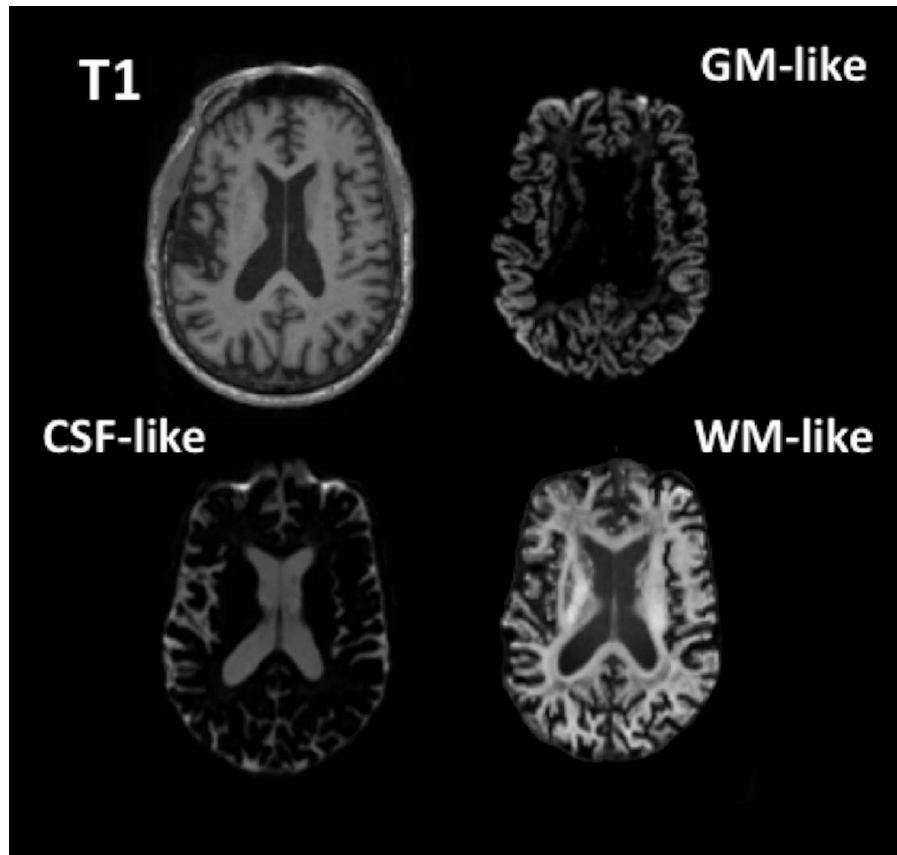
Axial slices showing a T1-weighted MPRAGE and the GM-, CSF-, and WM-like tissue compartments derived from the dMRI data using 3-tissue CSD.
